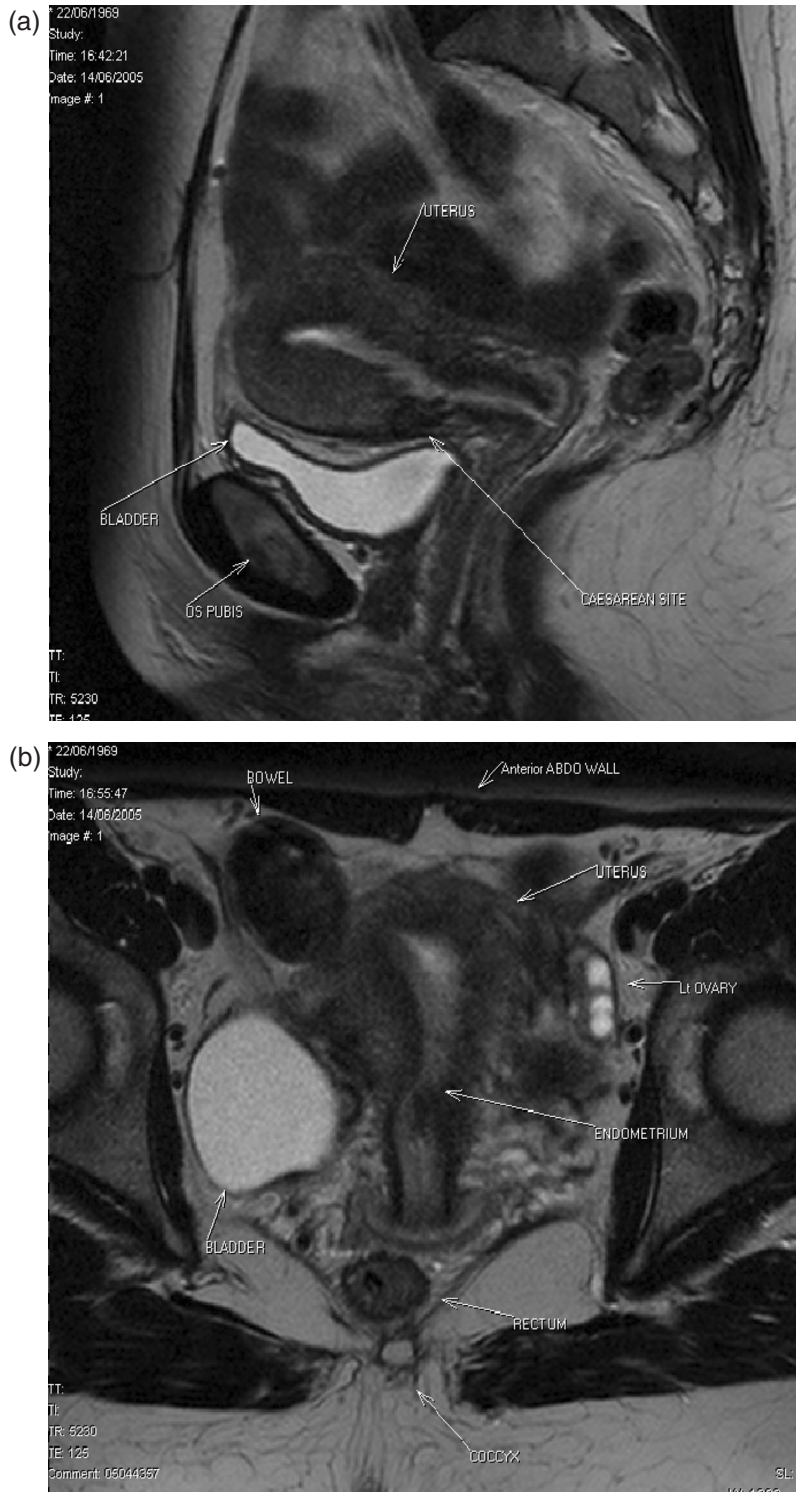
Normal MRI 6 months after massive postpartum hemorrhage treated by B-Lynch surgical technique followed by uneventful spontaneous vertex vaginal delivery 22 months later. (a) Sagittal view showing normal endometrial cavity and treated Cesarean incision site; (b) coronal view, with no uterine cavity synechiae¹⁹; (c) view at level of incision for Cesarean section, showing well-healed features
